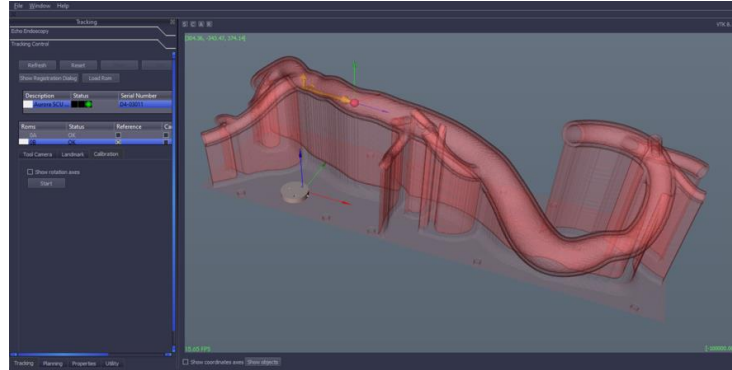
The navigation software presenting the 3D rendering of the model from CT scans and the catheter tip position displayed in quasi real time.
